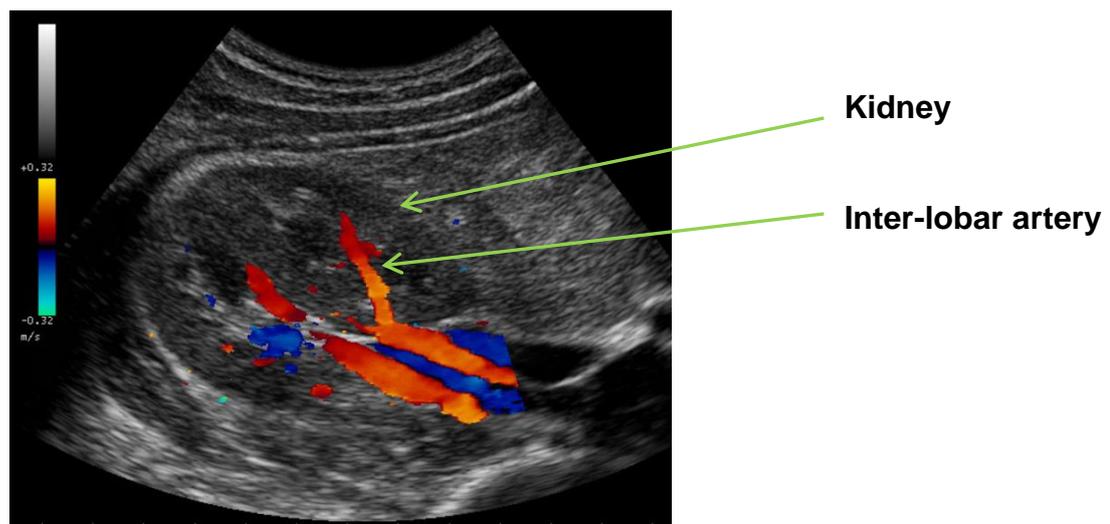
Conventional colour Doppler. Flow towards the transducer is coded as red. Flow away from the transducer is coded as blue.
